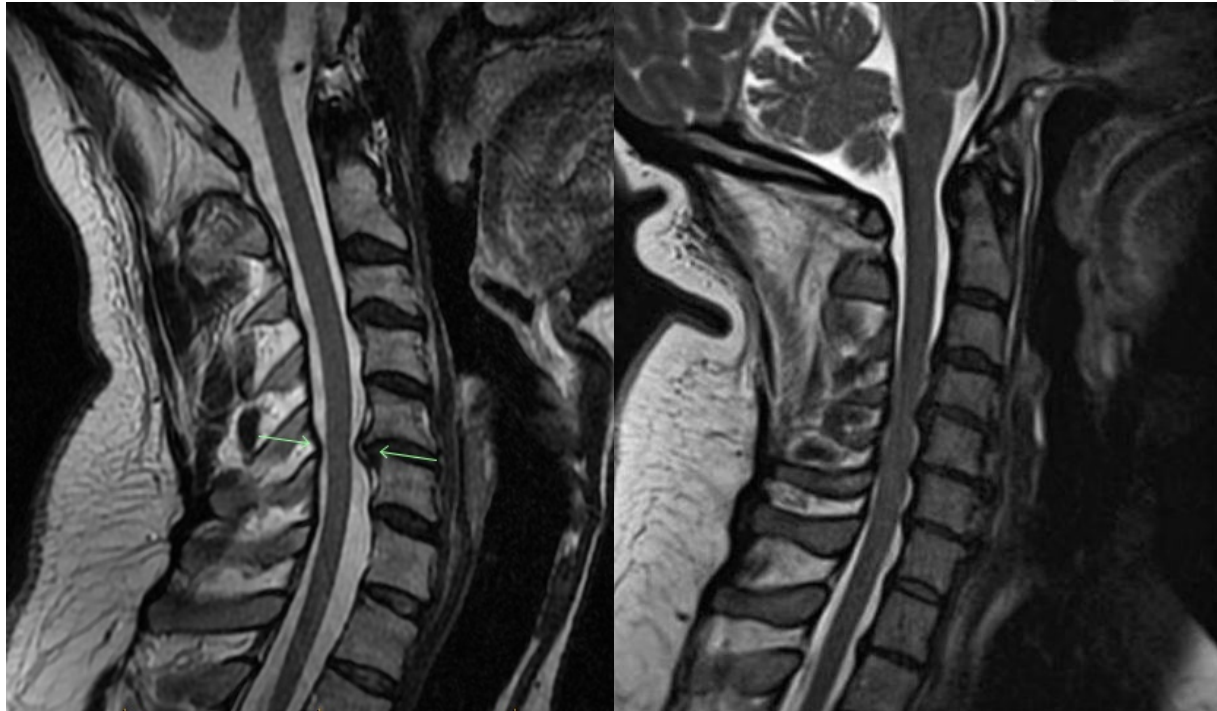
Preoperative and post operative MRI
